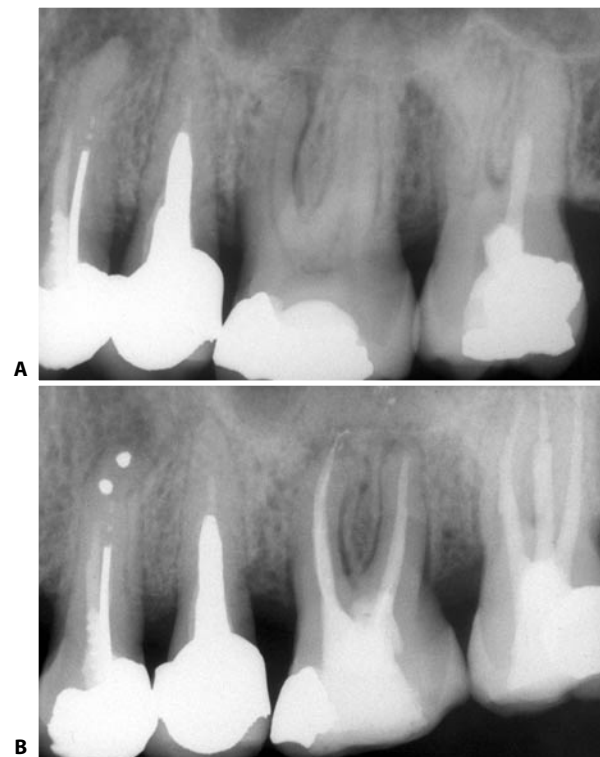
The palatal root of this first upper molar has to be removed, therefore the tooth needs to be endodontically treated. A. Preoperative radiograph. B. 12 month recall.
